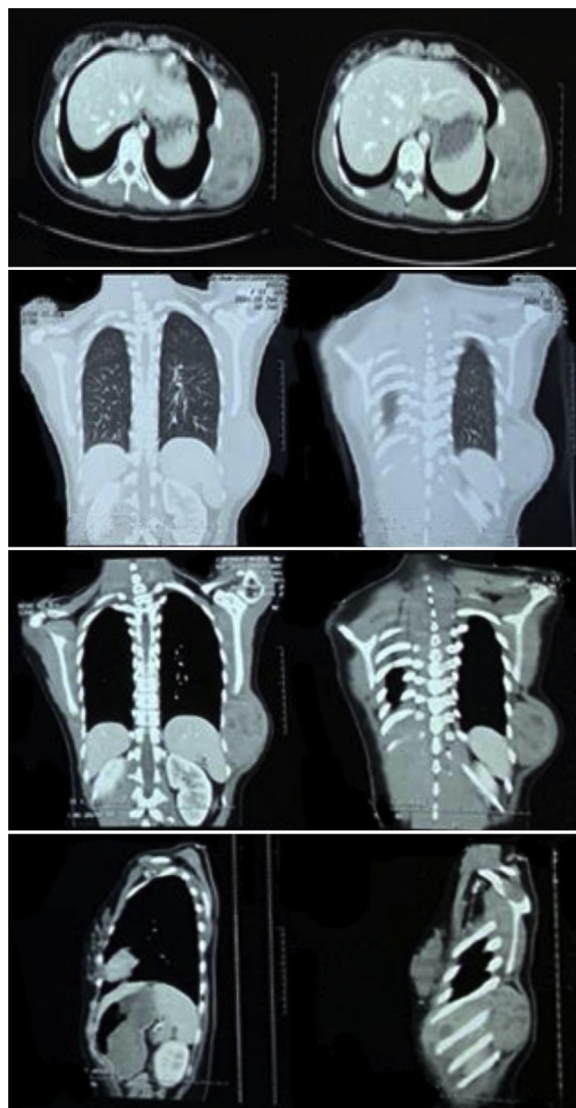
CT-scan of the Thorax: mass on the anteromedial of the right chest wall infiltrating the ribs and attached the left lung.
